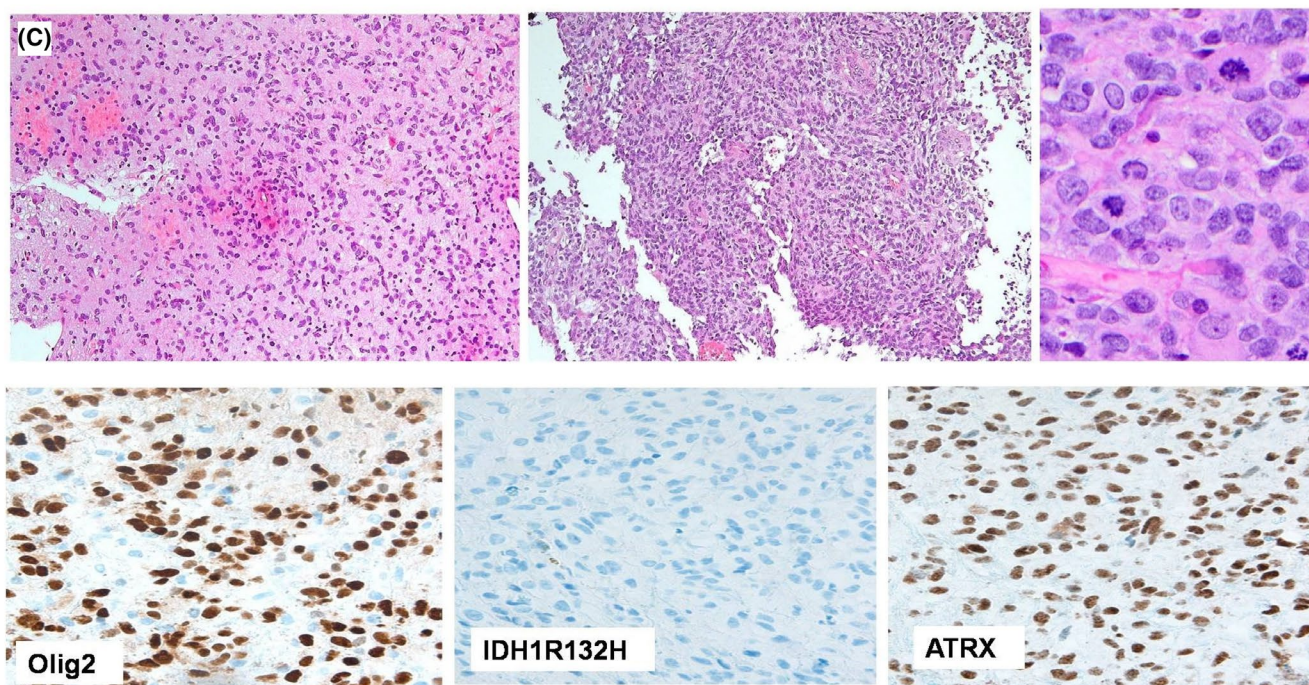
Tumor epilepsy case history: male, aged 50 years. Two-month history of focal seizures characterized by the sudden onset of visual hallucinations (scenes of his life flowing back in quick succession from adulthood to infancy) strictly confined to the right visual hemifield, sometimes evolving to tonic-clonic seizures. (A) Electroencephalogram showing left posterior slow activity intermingled with rare slow spikes. (B) Magnetic resonance imaging showing left posterior high-grade glioma. (C) Neuropathological examination: diffuse astrocytic glioma, isocitrate dehydrogenase (IDH) wild-type, and H3 wild-type, showing high mitotic activity and microvascular proliferation, and a TERT promoter mutation (c.-146C>T; C250T, VAF 59%), corresponding to a glioblastoma, IDH wild-type, grade 4, according to World Health Organization 2021.
